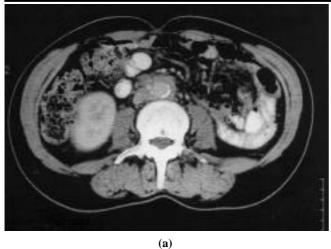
(a) Post-contrast CT of the abdomen at the level of the lower pole of the right kidney demonstrates a mildly enhancing mantle of soft tissue density encasing the abdominal aorta. There is atheromatous calcification of the aortic wall. (b) Non-contrast CT at the same level, two months later. The mantle of soft tissue density has decreased in size. The definition of the aortic wall margin is poor.
